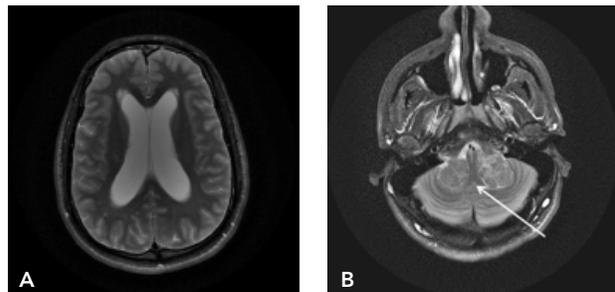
A) Axial T2 fat saturated MRI at the level of the lateral ventricle (left). B) Axial T2 fat saturated MRI at the level of the inferior 4th ventricle, with arrow revealing near-complete obliteration of the 4th ventricle (right).
